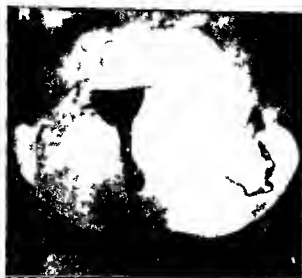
Roentgenogram of the female reproductive system showing the uterus and fallopian tubes. The image is a high-contrast black and white photograph with some text artifacts at the bottom.
